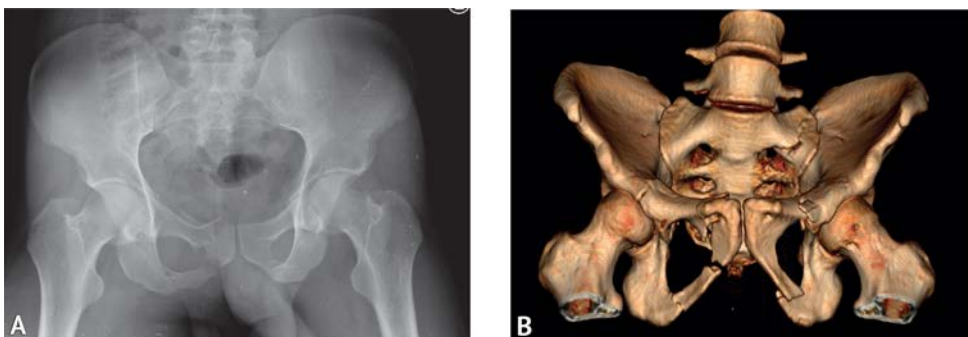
Plain radiograph of the pelvis (A); 3D reconstruction from a pelvic CT scan in the anteroposterior view (B)
